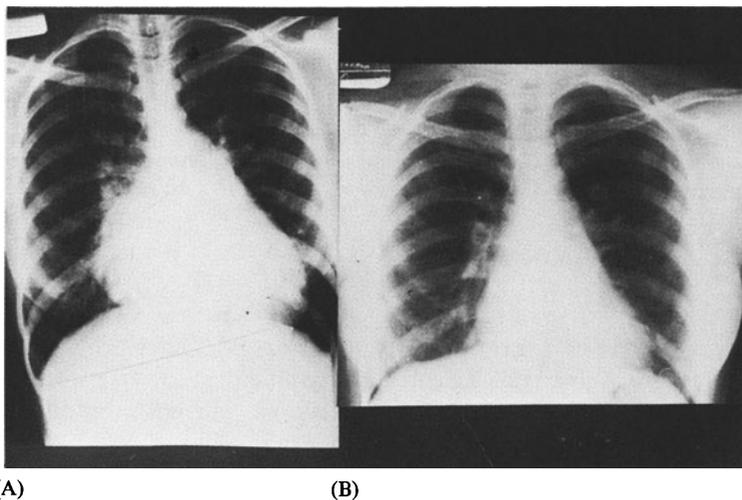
(A) Distinctive radiologic profile in a young patient with severe mitral incompetence showing pronounced cardiomegaly. (B) X-ray film of the same patient with a Starr–Edwards ball valve prosthesis in place.
